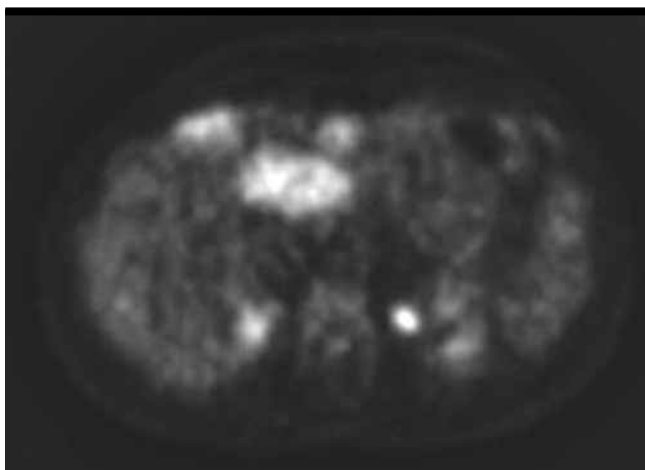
Axial PET-CT image. All lesions show intense ^{18}F -FDG uptake
